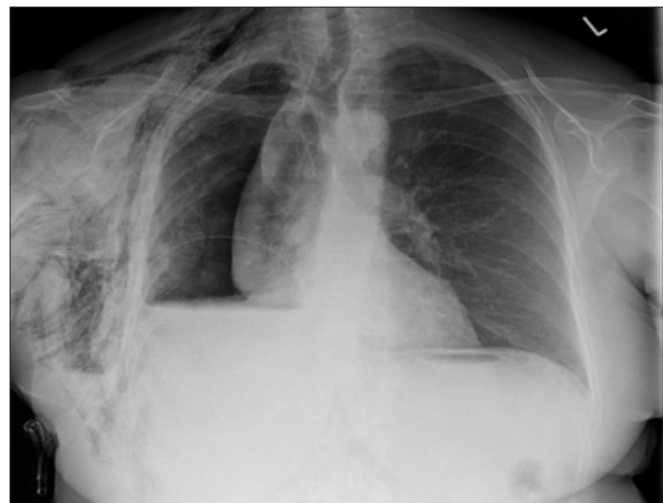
Chest X-ray of the patient on admission to Accident and Emergency.
